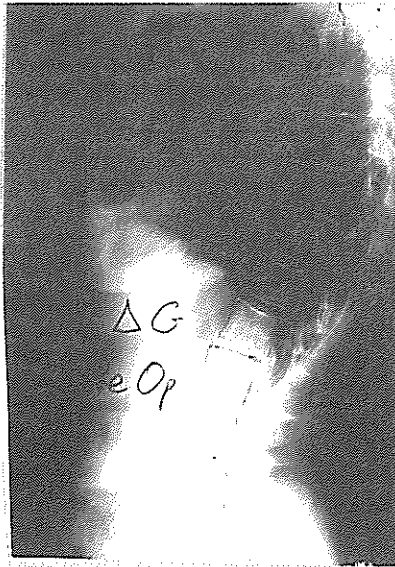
Lateral X-ray of the same patient showing decrease Lordosis.
